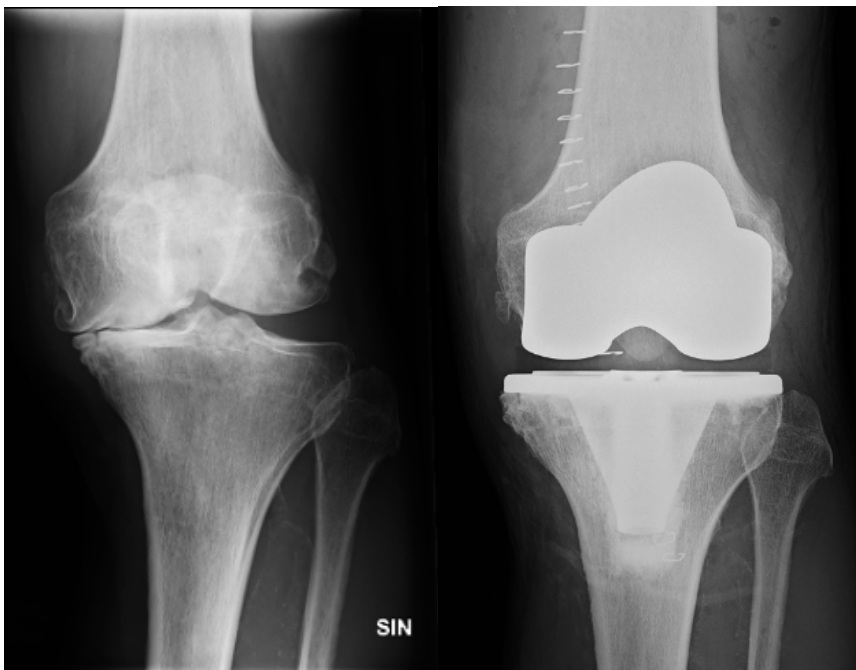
An AP radiograph of the left knee demonstrating severe knee osteoarthritis (OA) with medial joint space narrowing, osteophytes and subchondral sclerosis (left). A radiograph of the same knee after cemented TKR (right).
